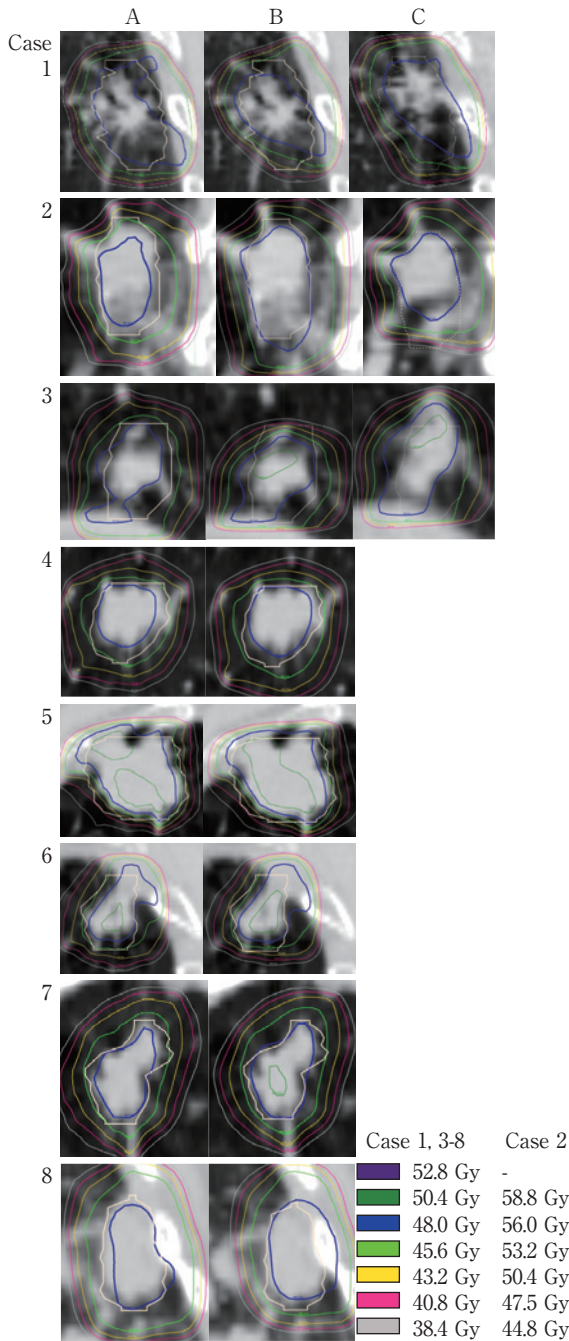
Dose distribution for the 8 patients. All CT images are coronal views.
